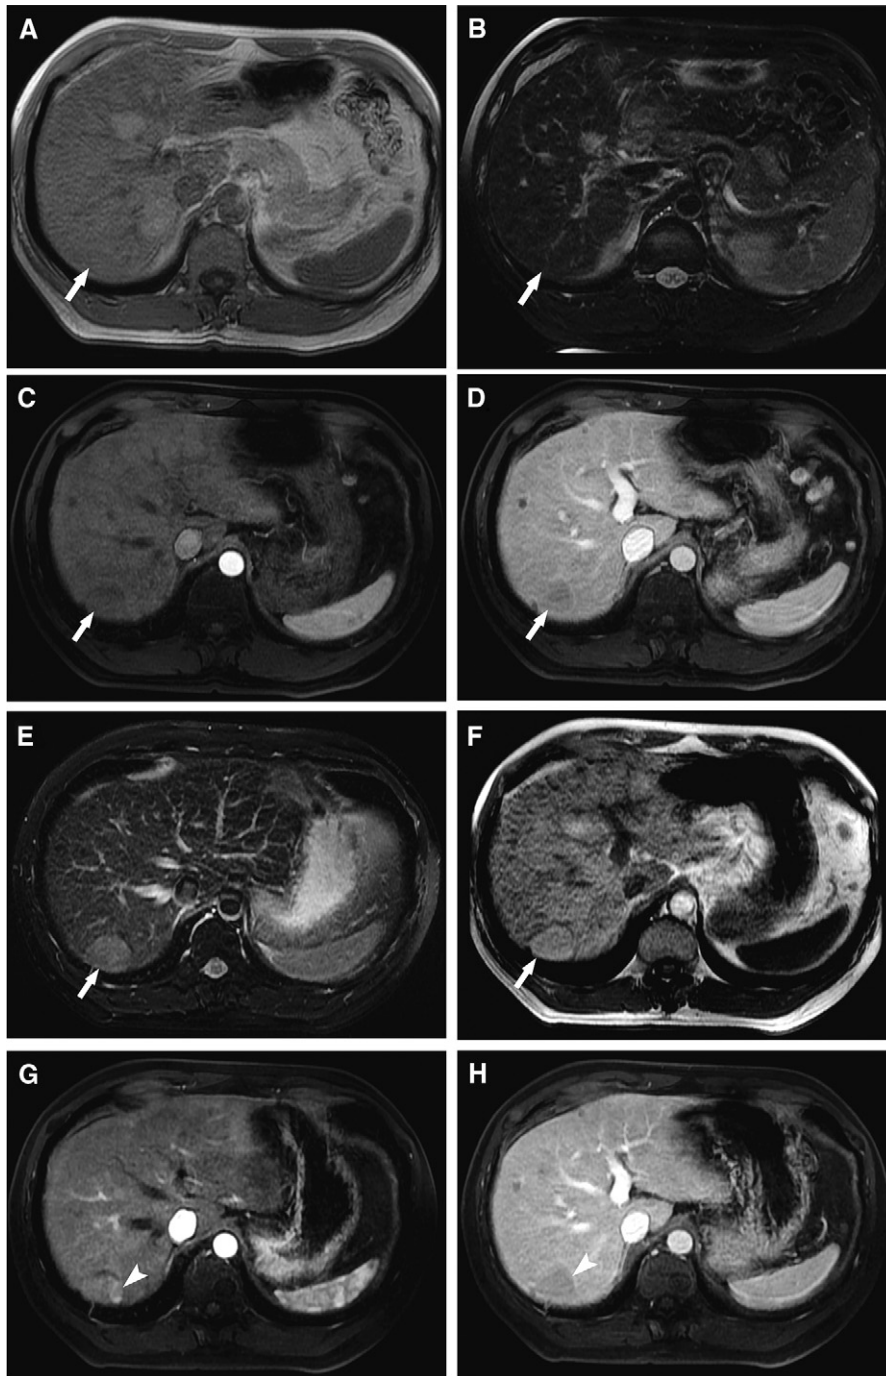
(A) Axial gradient echo T1 out-of-phase image, demonstrating a subtle isointense lesion (arrows) within segment 6, which, on the T2-weighted sequence, is also isointense to the liver parenchyma (B). (C) Gadolinium-enhanced liver acceleration volume acquisition (LAVA) magnetic resonance imaging (MRI) during the arterial phase, making the lesion (arrows) slightly more conspicuous but does not demonstrate enhancement on this phase, nor the portal venous phase (D), and is consistent with a regenerative nodule. (E) T2-weighted MRI sequence on 1-year follow-up with the segment 6 lesion (arrow) now hyperintense compared with the liver parenchyma. (F) Axial gradient echo T1 in phase image, demonstrating that the nodule is now of increased signal intensity. (G) Gadolinium-enhanced LAVA MRI sequence, demonstrating a focus of nodular arterial enhancement along its medial aspect (arrowheads) consistent with the “nodule in nodule” appearance. This focus washes out and is hypointense to liver parenchyma on the portal venous phase (H), consistent with a focus of malignant transformation within this nodule.
